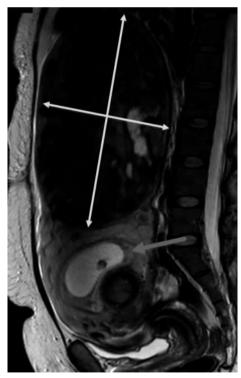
Pelvic and abdominal T2-weighted MRI, sagittal plane of a fibroid measuring 24×18 cm.
